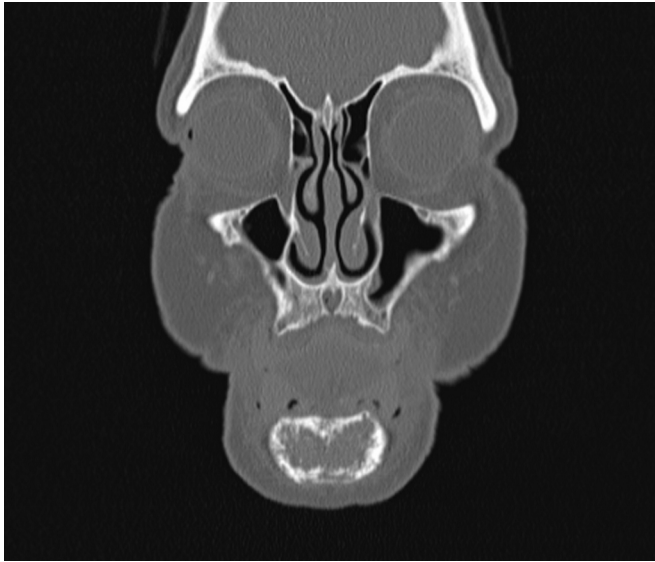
CT scan - Coronal section: osteolytic lesion in the anterior region of the mandible, and significant thinning of the cortical bone.
